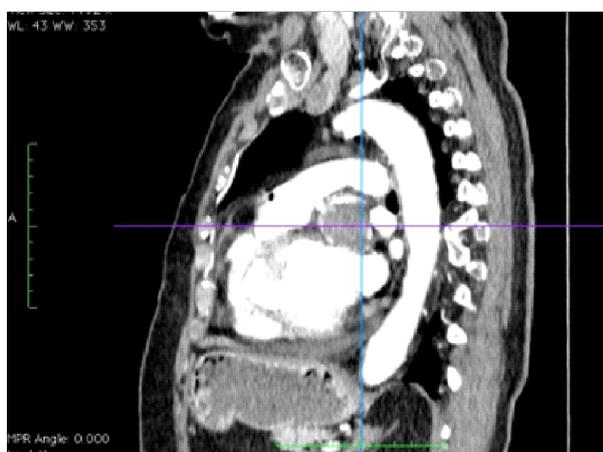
Multislice computed tomography with contrast. Sagittal multiplanar reconstruction. Giant aneurysm of the left circumflex coronary artery with thrombus.
